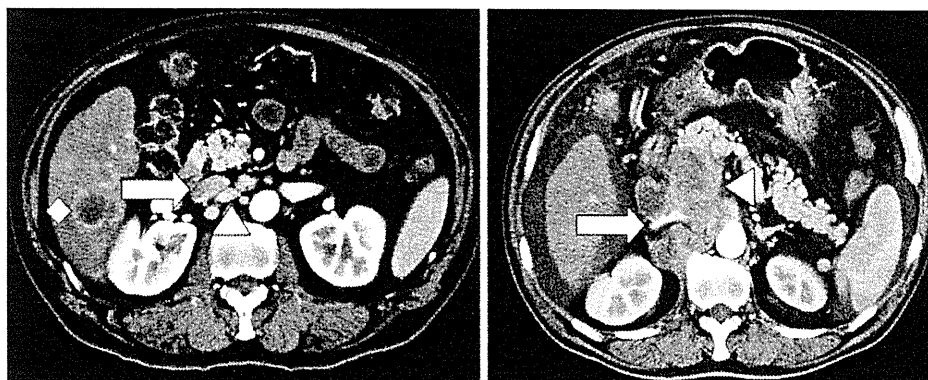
Computed tomography findings of inferior vena cava obstruction by huge metastatic lymph nodes from hepatocellular carcinoma. *Left* A 57-year-old female underwent proton beam therapy for her solitary HCC (diamond). The slightly enlarged lymph nodes
